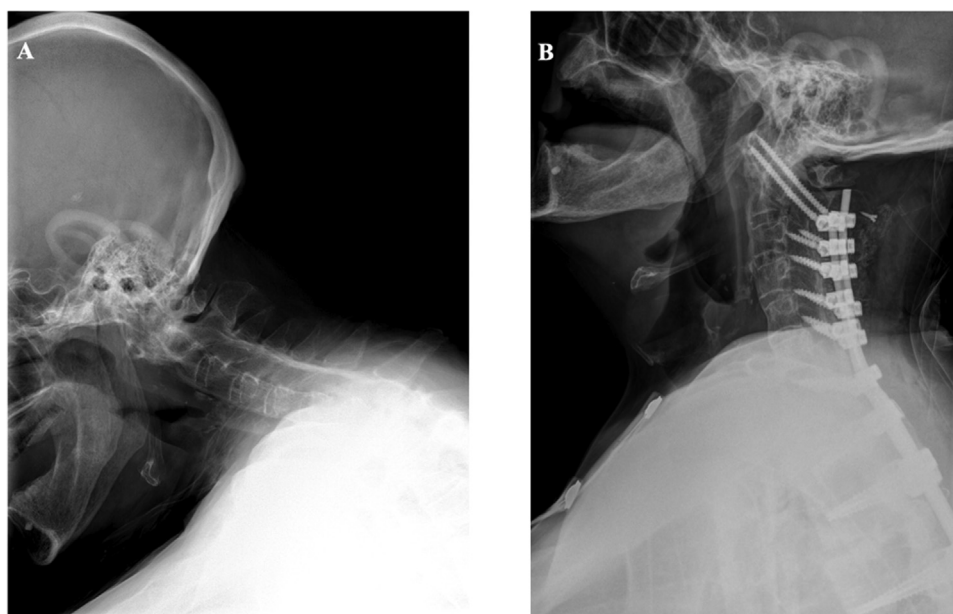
(A–B): Pre-operative lateral cervical spine X-ray of 75-year-old male with chin-on-chest deformity due to ankylosing spondylitis (A). Post-operative X-ray of the same patient after a T1-T4 osteotomy with internal fixation (B).
